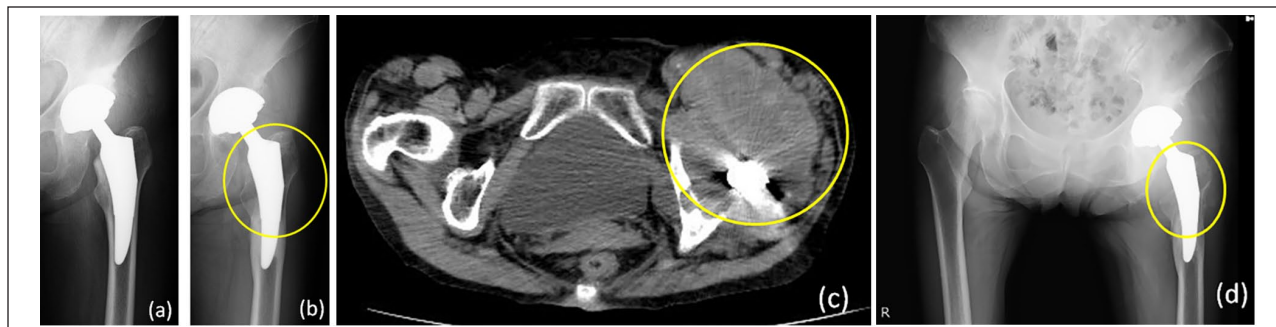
Postoperative radiography of a 68-year-old female patient who underwent MoM THA of the left hip using M2a Taper with head-size of 32 mm. The patient experienced no complications until 8 years postoperatively, when she developed left hip pain. At that time, focal osteolysis at the femur and the acetabulum were recognized by radiography (Figure 3(a) and (b)). A CT scan and radiography at 9 years postoperatively showed a pseudotumor around the stem and further advanced osteolysis at the femur (Figure 3(c) and (d)). The patient subsequently underwent reoperation changing the bearing surface to highly cross-linked polyethylene, and intraoperative findings were consistent with ARMD. (a) Postoperative X-ray. (b) X-ray performed 8 years postoperatively shows osteolysis (yellow circle) of the femur and acetabulum. (c) A CT scan performed 9 years postoperatively shows a pseudotumor (yellow circle) around the proximal stem. (d) X-ray performed 9 years postoperatively shows further advanced osteolysis at the femur.
